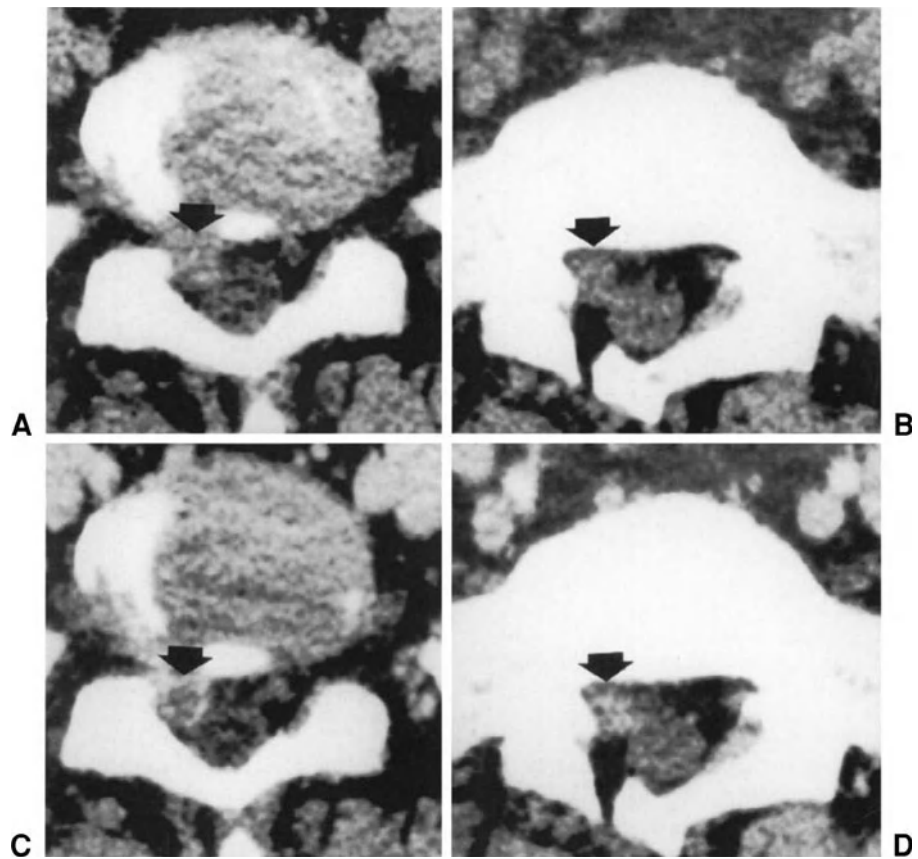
Right L5-S1 recurrent disc herniation (same level and side). (A) and (B) Axial CT scans obtained in basal conditions: a soft tissue isodense compared to the disc is visible in the spinal canal, on the right (arrows). (C) and (D) After administration of contrast medium, density of the tissue (arrows) shows no significant changes.
